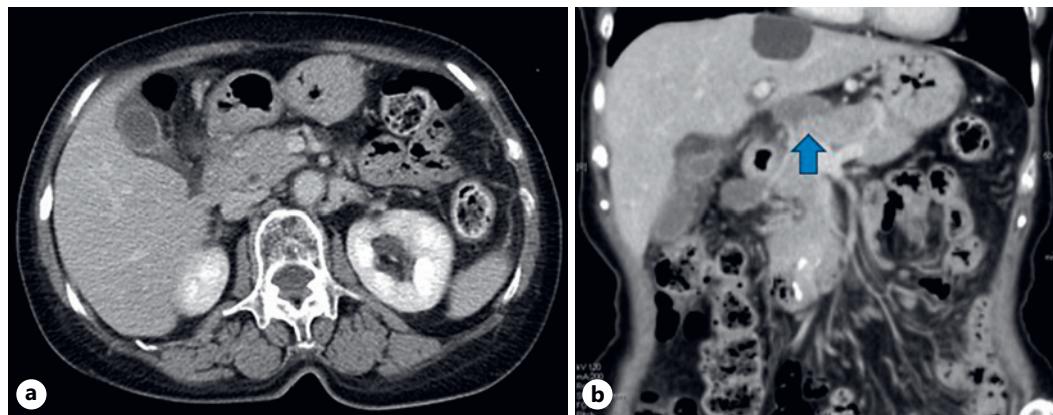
CT images to evaluate efficacy 3 months after the start of primary treatment. a Improvement in wall thickening of the primary lesion in the vestibular area was observed. b The lesser curvature lymph node showed a reduction to 16 mm (blue arrow).
